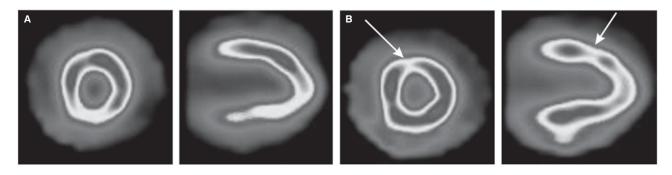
Example of an artifact (arrows) in anterior wall on transversal and sagittal SPECT tomograms after attenuation correction. A. Before attenuation correction; B. After attenuation correction.
